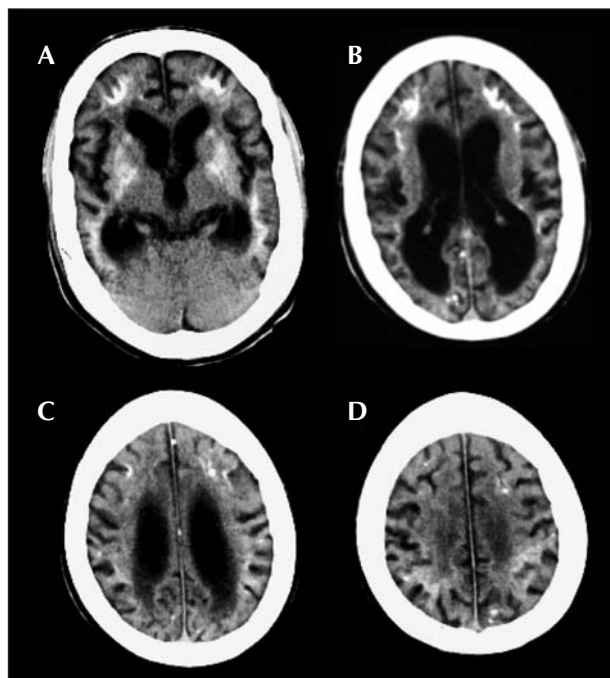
CT scan at age 18 years. A) Bilateral calcification of basal ganglia and periventricular white matter. There is supratentorial atrophy with enlarged ventricles and subarachnoid spaces. B) Periventricular calcifications and calcification in occipital cortex. C) and D) show multifocal, small, cortical calcifications.
